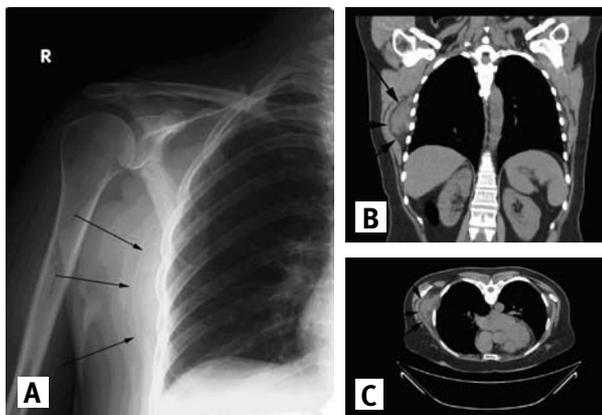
Radiographic findings. [A] X-ray, antero-posterior view. [B] CT findings, coronal view and [C] sagittal view; black arrows indicate the mass
